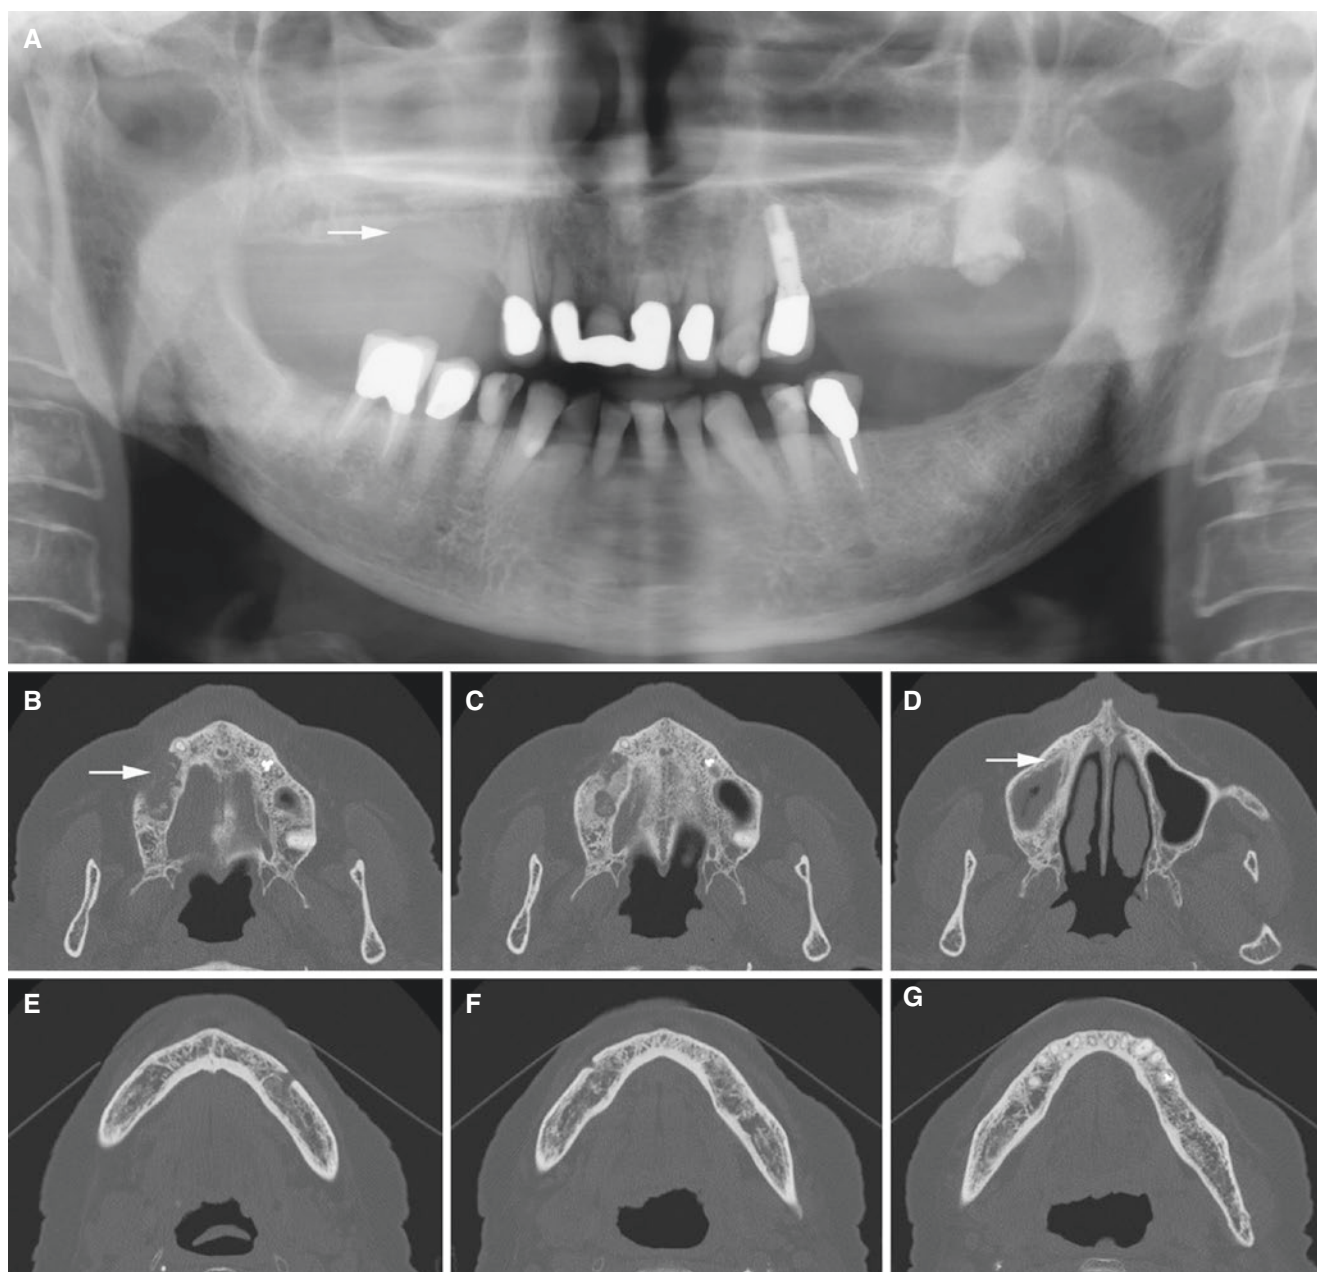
Medication-related osteonecrosis, maxilla; 78-year-old female (osteoporosis, more than 10 years with antiresorptive therapy); loose teeth with pus recently removed from the right maxilla. (A) Panoramic view shows diffuse destruction (*arrow*). (B, C) Axial CT
